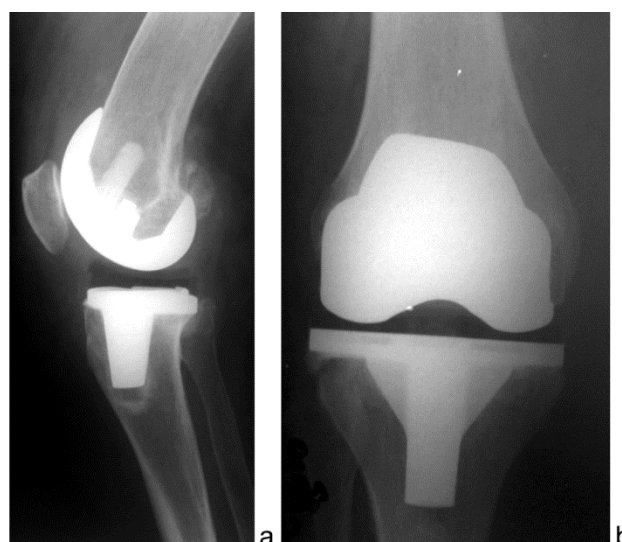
Radiographs of the right knee joint of patient G. following TKA: a – lateral view, b – AP view
